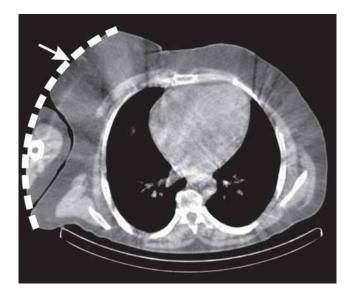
Example of transversal CT tomograms used for the purose of creation of attenuation correction map. Thick white dotted line shows a line of image truncation (limit of a field of reconstruction). A part of patient's right breast is outside of image recontruction field.
